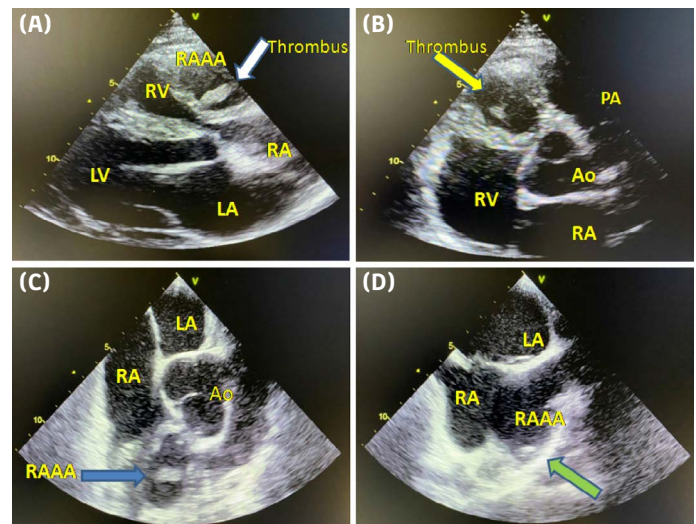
(A) Transthoracic echocardiography, longitudinal axis view: an aneurysmal structure with suspected thrombus is observed in the upper vicinity of the right ventricle (white arrow). (B) Transthoracic echocardiography, short axis view: an aneurysmal structure with suspected thrombus is observed between the right ventricle and right atrium (yellow arrow). (C) Transesophageal echocardiography mid-esophageal view: a mobile echogenic structure is observed within the aneurysmal formation, adjacent to the aorta and right ventricle (blue arrow). (D) Transesophageal echocardiography, bicaval view: a right atrial aneurysm is visualized with a suspicious thrombus (green arrow).
